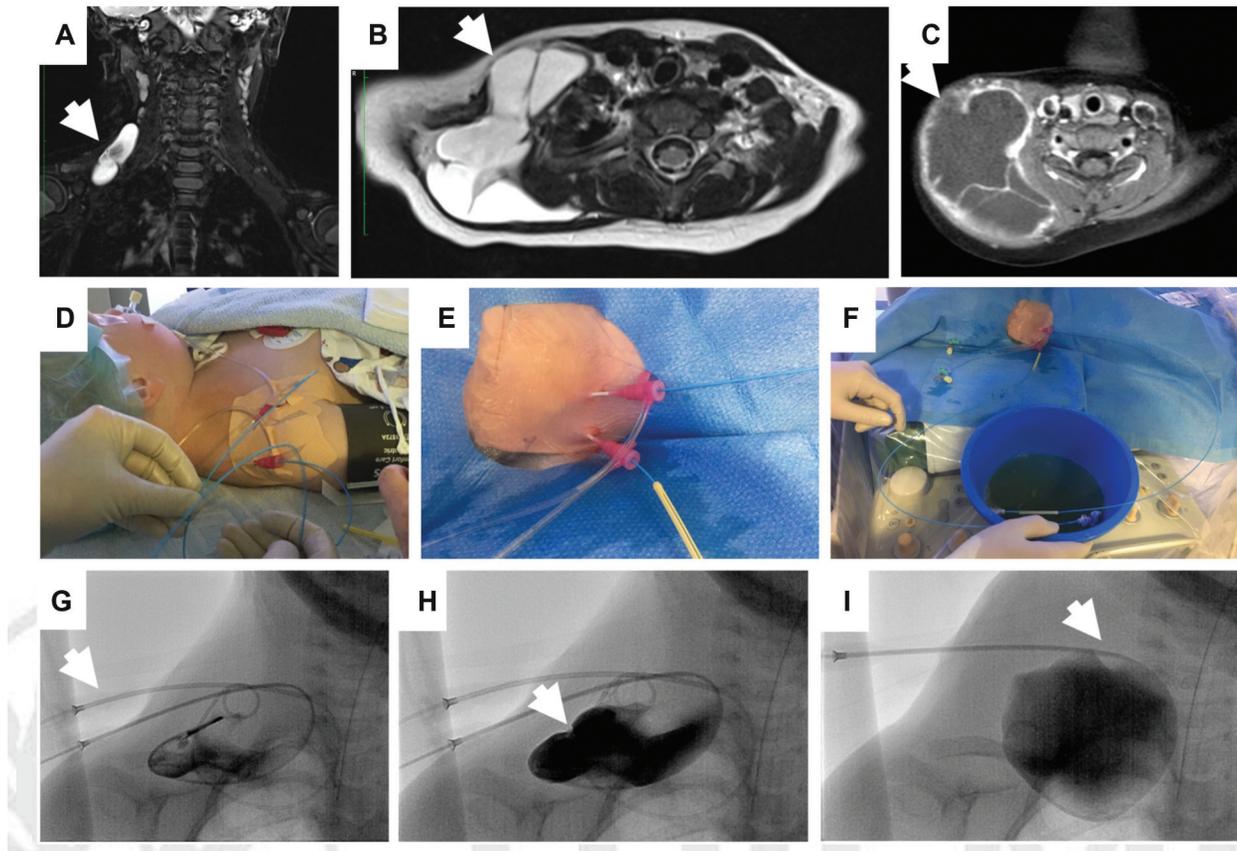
Percutaneous image-guided sclerotherapy of a cervicothoracic lymphatic malformation in a 3-year-old child. (A) Coronal T2-weighted fat-saturated MR image reveals (arrow) fluid levels indicative of recent hemorrhage. (B) Axial T2-weighted MR images present macrocystic lesion type with septal thickening (arrow) involving the right cervicothoracic area. (C) Following contrast application, only septal structures reveal prominent enhancement, while central lymphatic spaces do not fill with gadolinium. (D–H) Fluoroscopy-guided imaging and drainage of macrocystic lesions before inserting the sclerosing agent. (I) Percutaneous needle assessment and sclerotherapy using fluoroscopy guidance.
